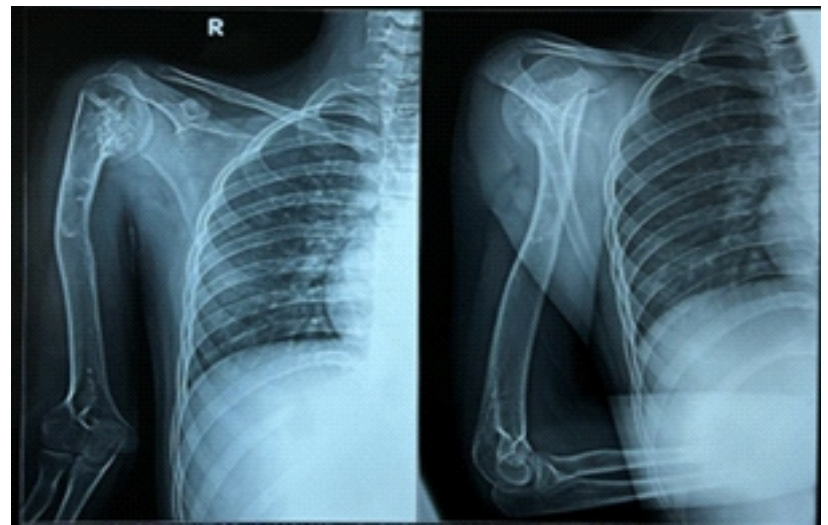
2 year follow up xray.
